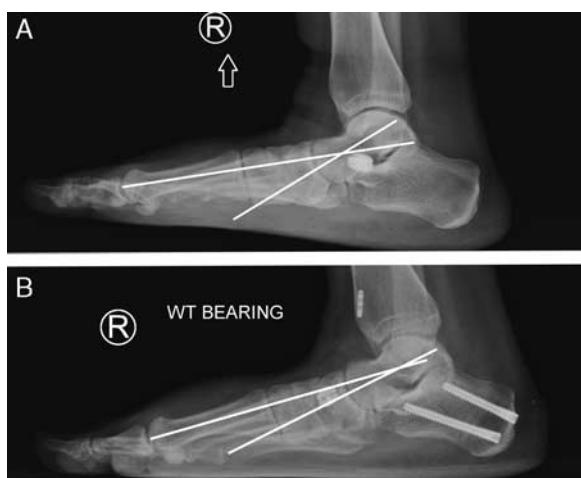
Preoperative (A) and 1-year postoperative (B) radiographs of a patient who had undergone a previous sinus tarsi implant placement. Note the improvement in Meary's angle.
